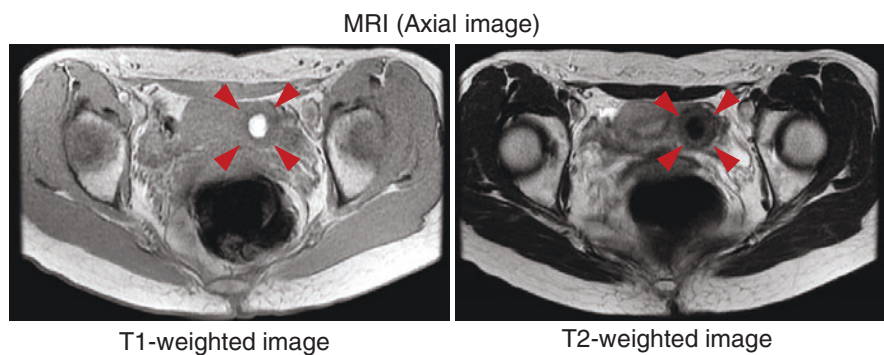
Magnetic resonance imaging (MRI) of cystic adenomyosis. T1- and T2-weighted axial images were demonstrated. Arrowhead, cystic adenomyosis
